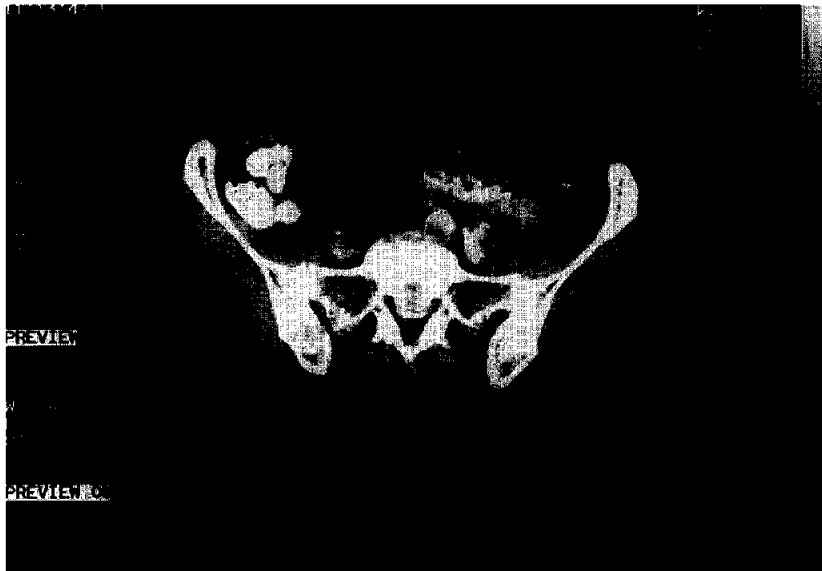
An 8 cm, air-filled mass is seen on CT scan. The mass was not enhanced by or filled with enteric contrast material.
